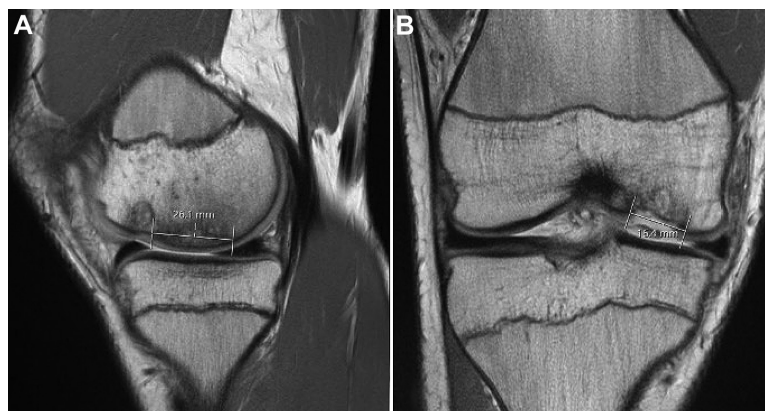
Lesion size, measured as the distance of the OCD lesion on (A) sagittal and (B) coronal MRI. MRI, magnetic resonance imaging; OCD, osteochondritis dissecans.
